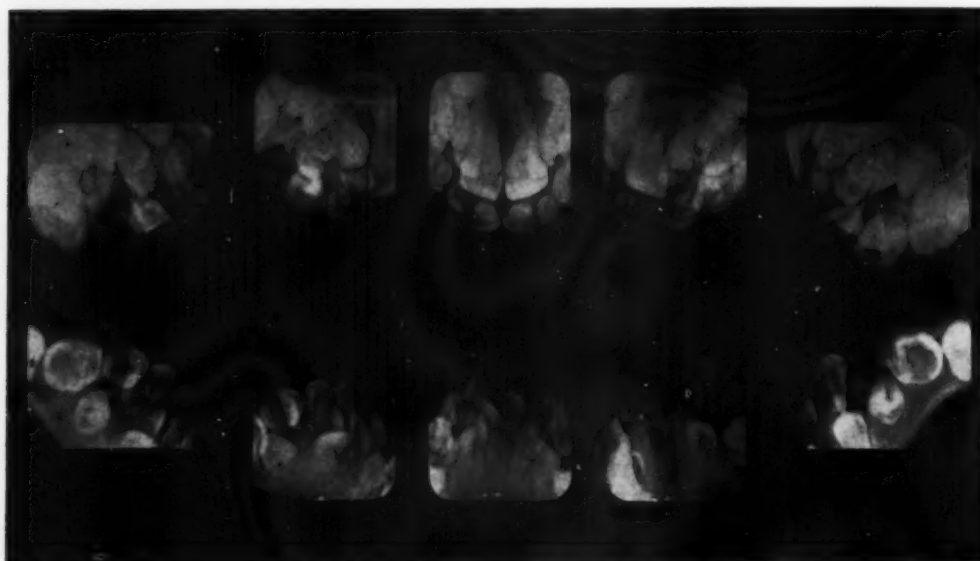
Progeria (Hutchinson-Gilford syndrome) in girl ten years of age. Roentgenogram shows prolonged retention of primary teeth and non-eruption of permanent teeth. The eruption age is approximately four years behind the chronologic age. (Reproduced, with permission, from Lovstedt, S. A.: Examples of Dental Dysplasia. *Am. J. Orthodontics.* 33: 625-629, August 1947.)
